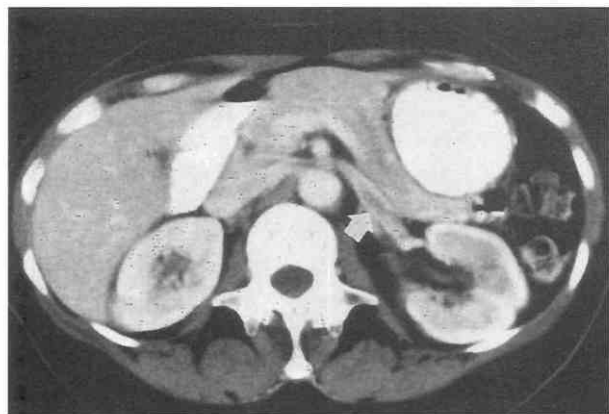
Renal vein thrombosis. Dynamic CT scan shows a low attenuation clot (*arrow*) in a partially thrombosed left renal vein. There is prolonged corticomedullary differentiation in the left kidney compared with the right kidney, which exhibits a homogeneous nephrogram. (From Birnbaum BA, Bosniak MA, Megibow AJ: Asymmetry of the renal nephrogram on CT: Significance of the unilateral prolonged cortical nephrogram. *Urol Radiol* 12:173-177, 1991.)
